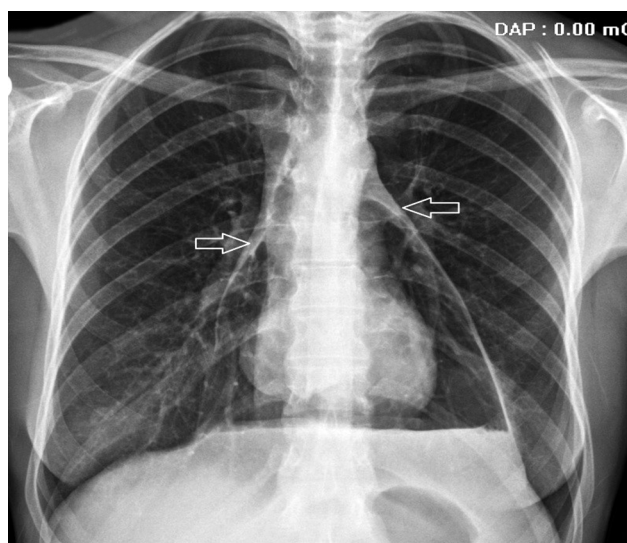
Chest radiograph demonstrating a radiolucent space along with a radiopaque border around the cardiac silhouette (arrows) representing pericardial air.
